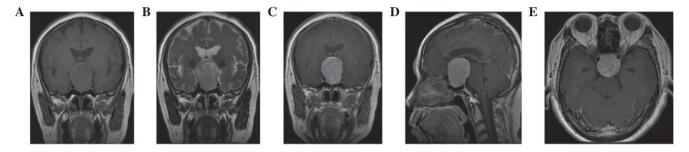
Magnetic resonance imaging findings of intrasellar schwannoma. The tumor appears as an (A) isointense T1WI and (B) slightly hyperintense T2WI mass, with remarkable heterogeneous enhancement on the (C) coronal, (D) sagittal and (E) axial planes. WI, weighted image.
